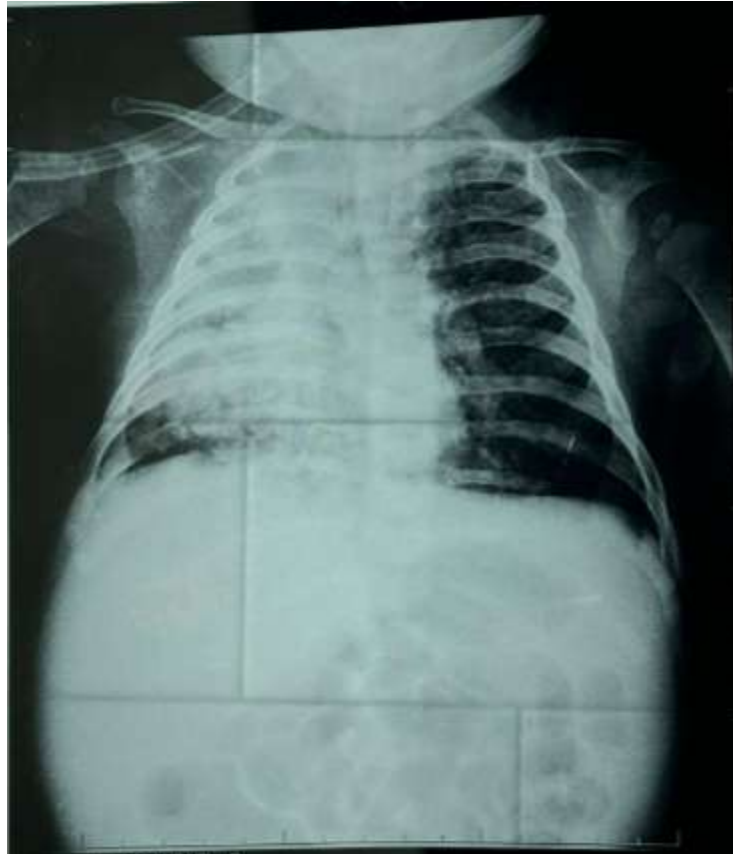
Frontal chest X-ray showing a “white lung” suggestive of massive alveolar syndrome.
